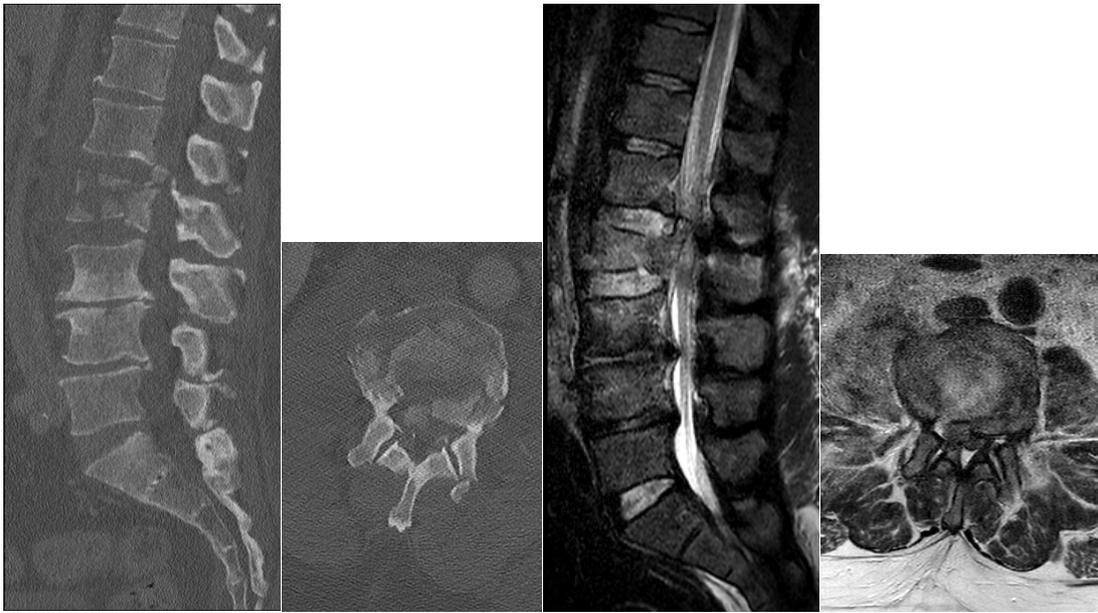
Complete burst fracture (two column injury, AO classification: A4, TLICS morphology – score 2). Sagittal (4a) and axial (4b) CT slices demonstrate a burst fracture of L2 which by definition involves the superior and inferior endplate, and the posterior vertebral cortex. There is significant comminution and fracture fragment retropulsion into the spinal canal. Sagittal STIR (4c) and Axial T2 (4d) demonstrate significant canal stenosis associated with the fracture but no significant signal changes within the PLC.
